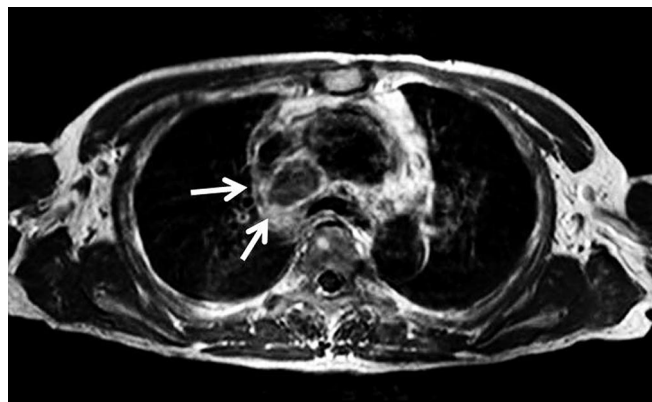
Magnetic resonance imaging. Mediastinal mass (arrows) had become slightly smaller 2 weeks later.
